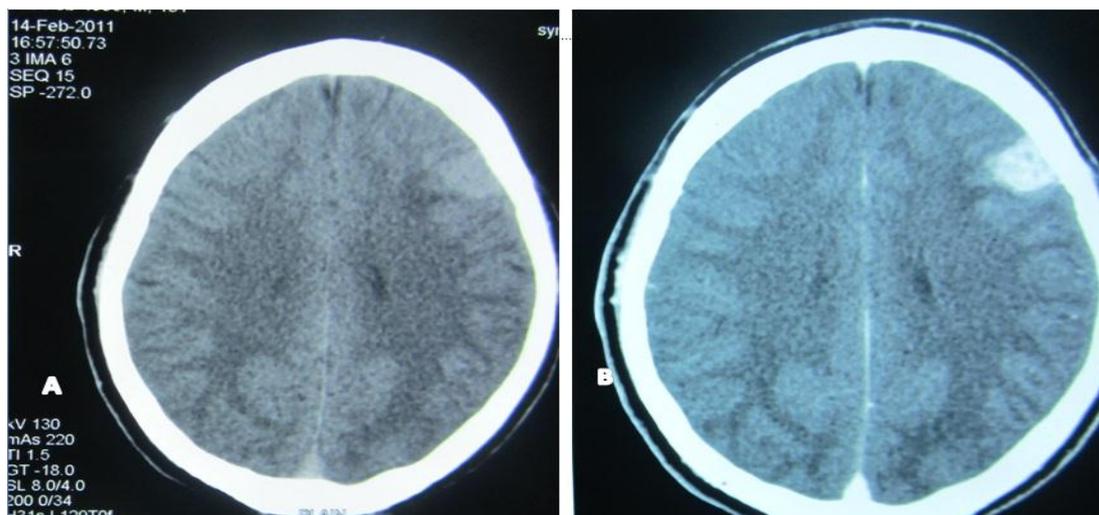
CT Brain plain (A) and contrast (B) taken in 2011 showing hyperdense lesion which is enhancing on contrast administration present in left frontal region with perilesional edema.
